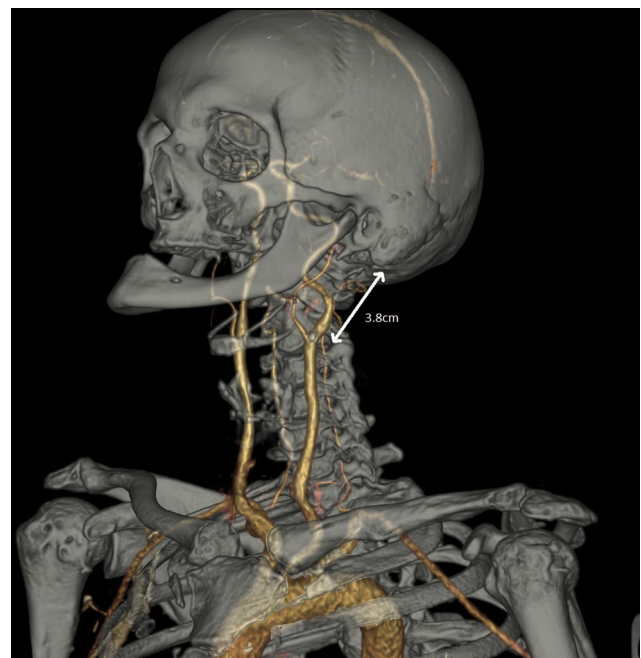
Sixty seven year old patient with severe proximal right internal carotid artery stenosis (NASCET 80%). Three dimensional volume rendering reconstruction of the pre-operative supra-aortic trunks computed tomography angiogram demonstrated a high right carotid bifurcation, located 3.8 cm under the level of the mastoid. However, due to the particular configuration of the mandible clearly documented on this image, this patient was not considered as having a higher operative risk.
